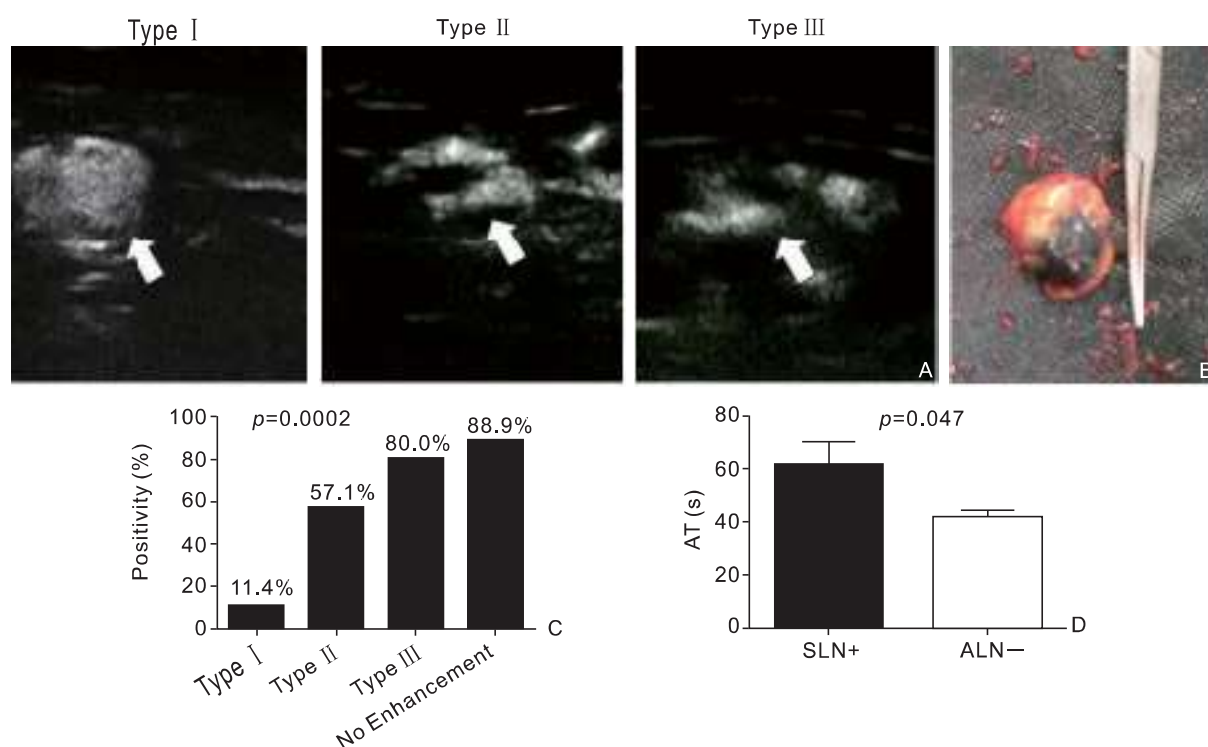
TLCEUS/blue dye injection method is sensitive and specific for SLNB. A) Different contrast pattern of SLNs observed by TLCEUS; B) Sample of dissected SLNs with obvious blue dye; C) Lymph nodes with type II and type III contrast pattern, and lymph nodes without enhancement are more likely to be metastasis positive; D) Positive SLNs showed a longer AT between contrast agent injection and lymph node enhancement than negative SLNs. TLCEUS, trans-lymphatic contrast enhanced ultrasound; SLNs, sentinel lymph node; AT, arriving time. A p value less than 0.05 is considered as statistically significant.
